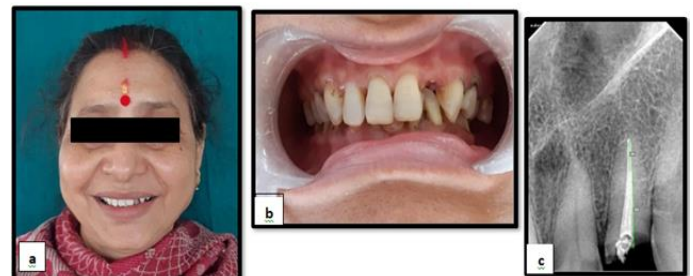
(a) Pre-operative profile image; (b) Pre-operative clinical photograph showing broken crown in maxillary left lateral incisor; (c) Preoperative radiographic image
